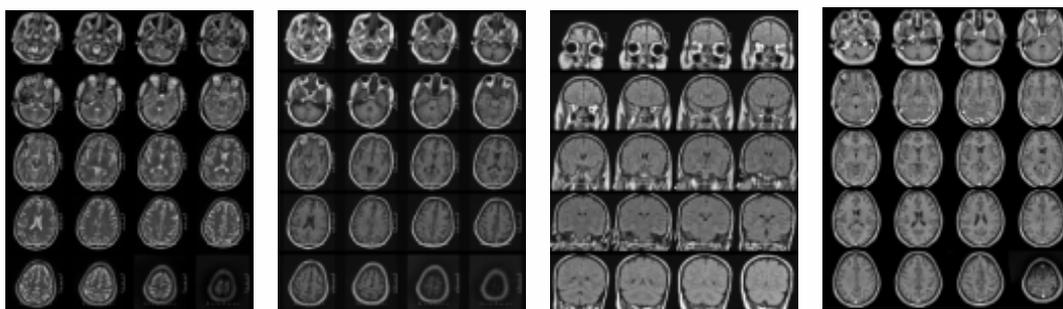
MRI brain with contrast on day 18
